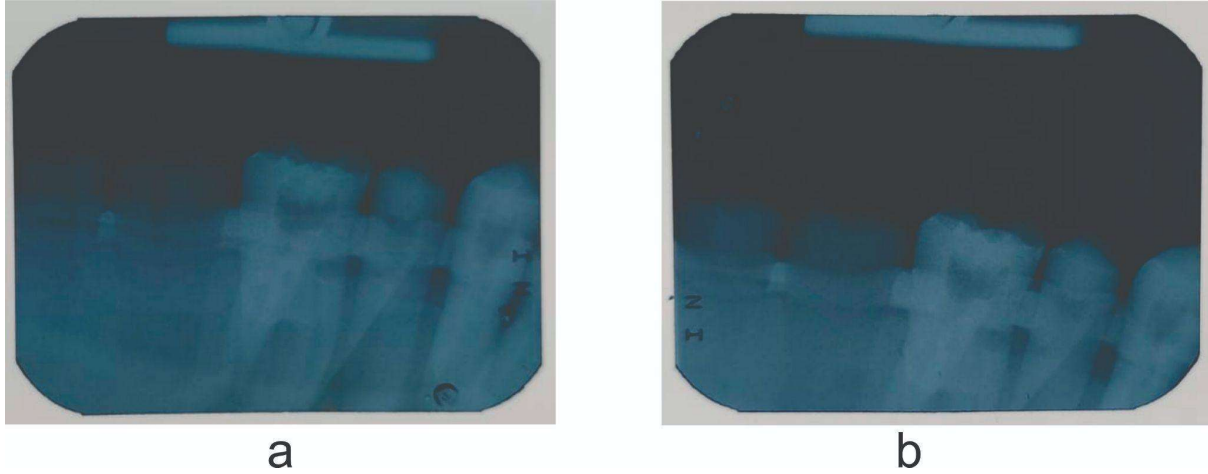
(a) Exposure of a periapical film on a MOM brand synthetic mandible without the collimator. (b) Exposure of a periapical film on a MOM brand synthetic mandible with the collimator.
